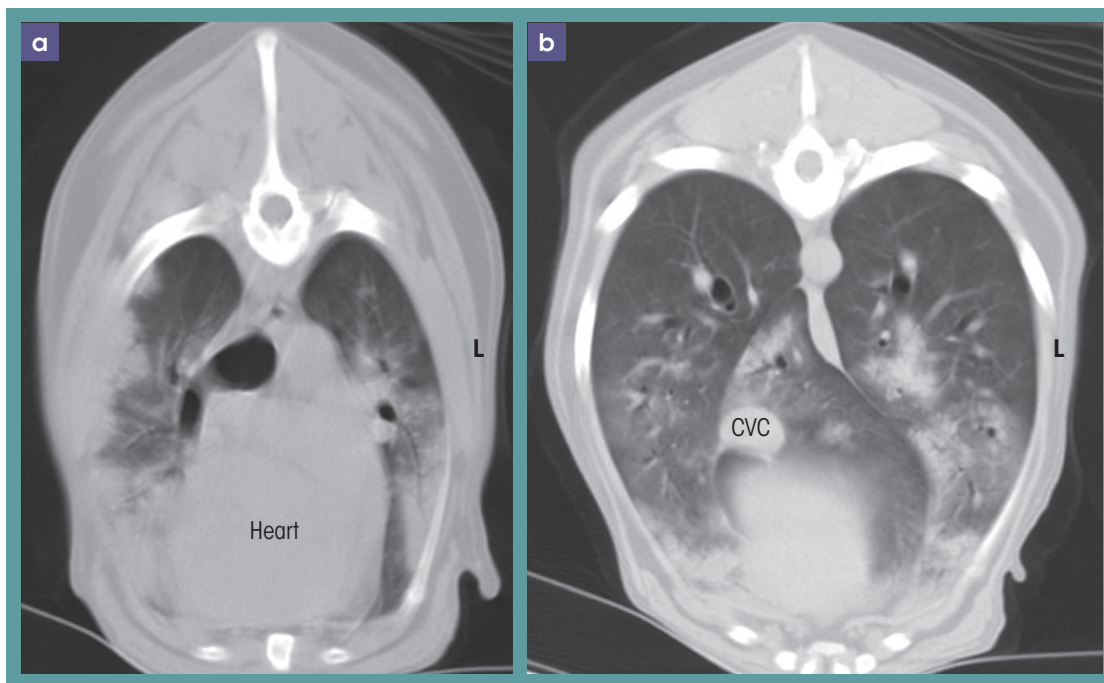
Transverse CT reconstructions in lung window at the level of the carina (a) and caudal vena cava (CVC) (b). Note the ill-defined, multifocal, peripheral and mainly ventral interstitial-alveolar infiltrates.
